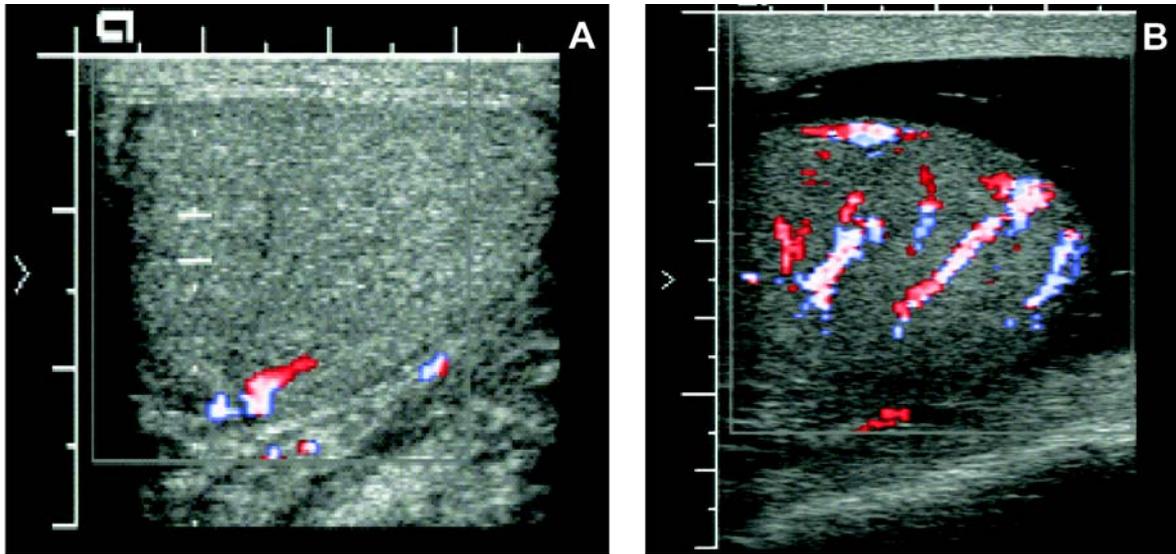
Testicular ultrasound showing a normal blood flow in the right testicle (A) and increased blood flow in the left testicle (B).
